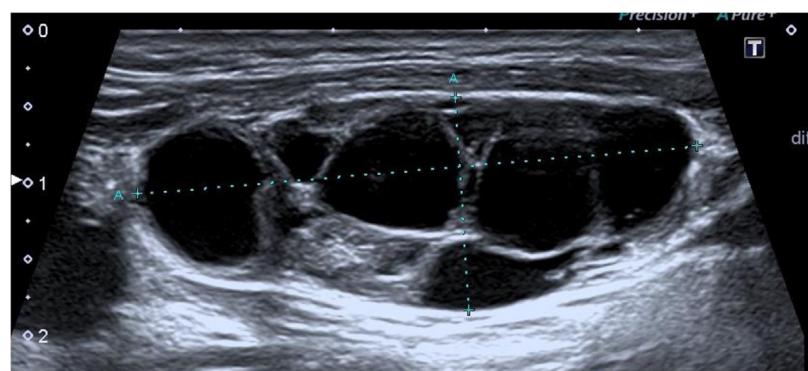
Ultrasound aspect of cystic cervical metastasis of a right sector-III papillary thyroid carcinoma. The hilum is not visible, and the lymph node is largely occupied by anechoogenic cystic pockets.
